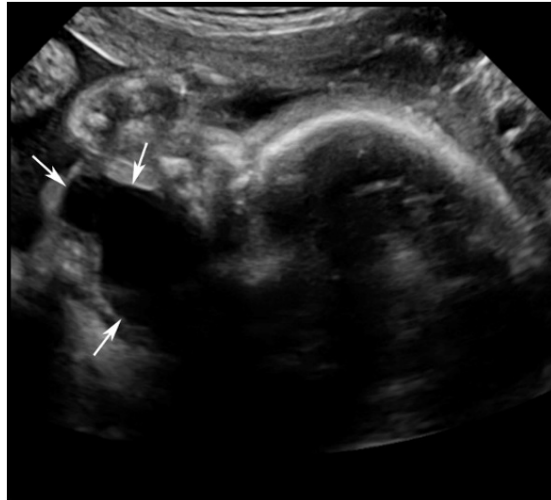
Ranula, Fetal Mouth. Ultrasound (Sagittal plane).
